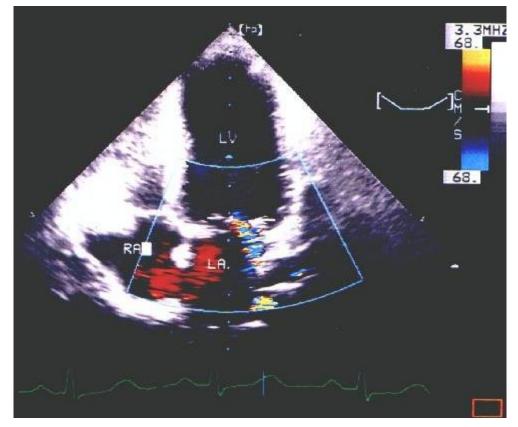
Transthoracic echocardiographic image mitral valve with mitral insufficiency secondary to prolapse
